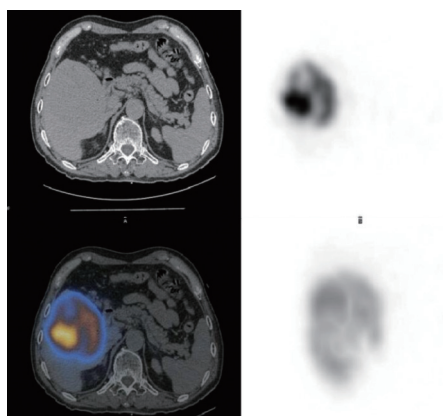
经肝动脉^{99m}Tc-MAA介入手术后SPECT/CT检查
